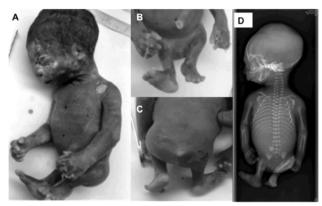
Postnatal findings. The fetus presented micrognathia, thin upper lip, short nose with broad tip, upstanding palpebral fissures (A), absent thigh (B), skin defect with a bone protrusion (C). Fetal X-ray: micrognathia and absent bilateral femurs, sacral hemivertebra with only three sacral vertebrae.
